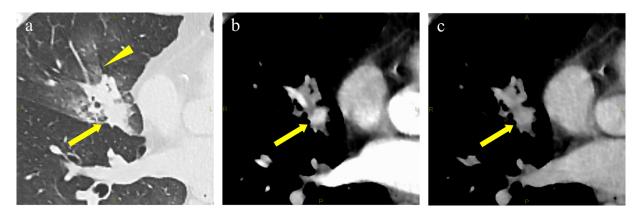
Contrast-enhanced computed tomography shows a 16-mm nodule (arrow) with peritumoral bleeding (arrowhead) in middle lobe of right lung (a). The nodule (arrow) has hypervascularity in early phase (b) and washout in the delayed phase (c). The lesion is suspected of a lung metastasis of renal carcinoma or vascular lesion.
